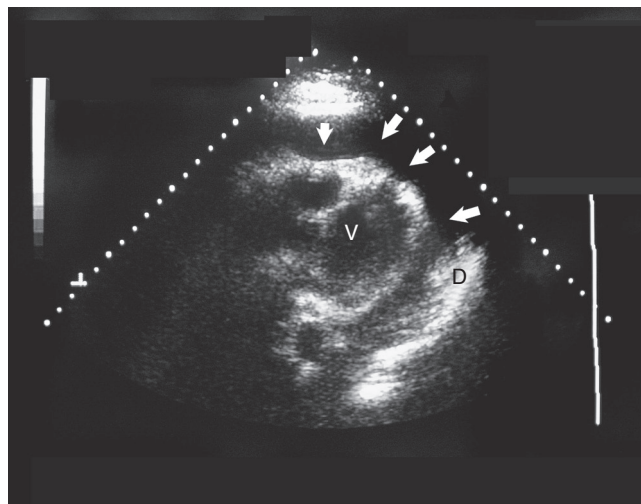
■ Echocardiogram shows a large pericardial effusion (arrows). D, Diaphragmatic pericardium; V, ventricle.
